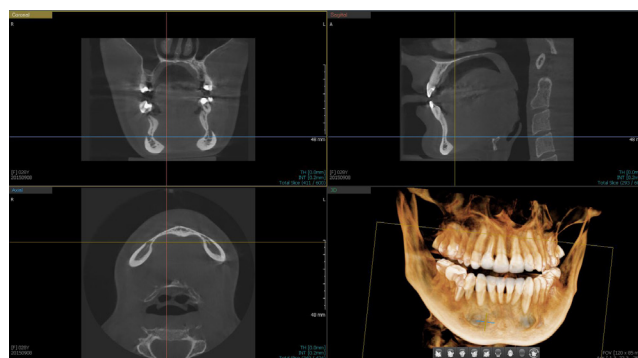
Case 2: Imaging of well-isolated, bilateral bone defects in the area of the mental spine of the mandible (CBCT)
